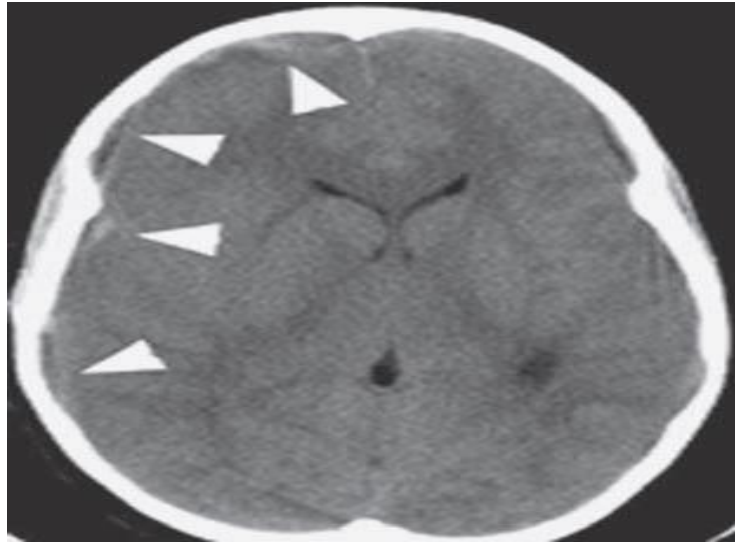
Leptomeningitis: dense haemorrhagic leptomeningeal collection over the right cerebral hemisphere (arrowheads), in a young patient with sinusitis (Interpretation of Emergency Head CT Erskine J. et.al 2008).
